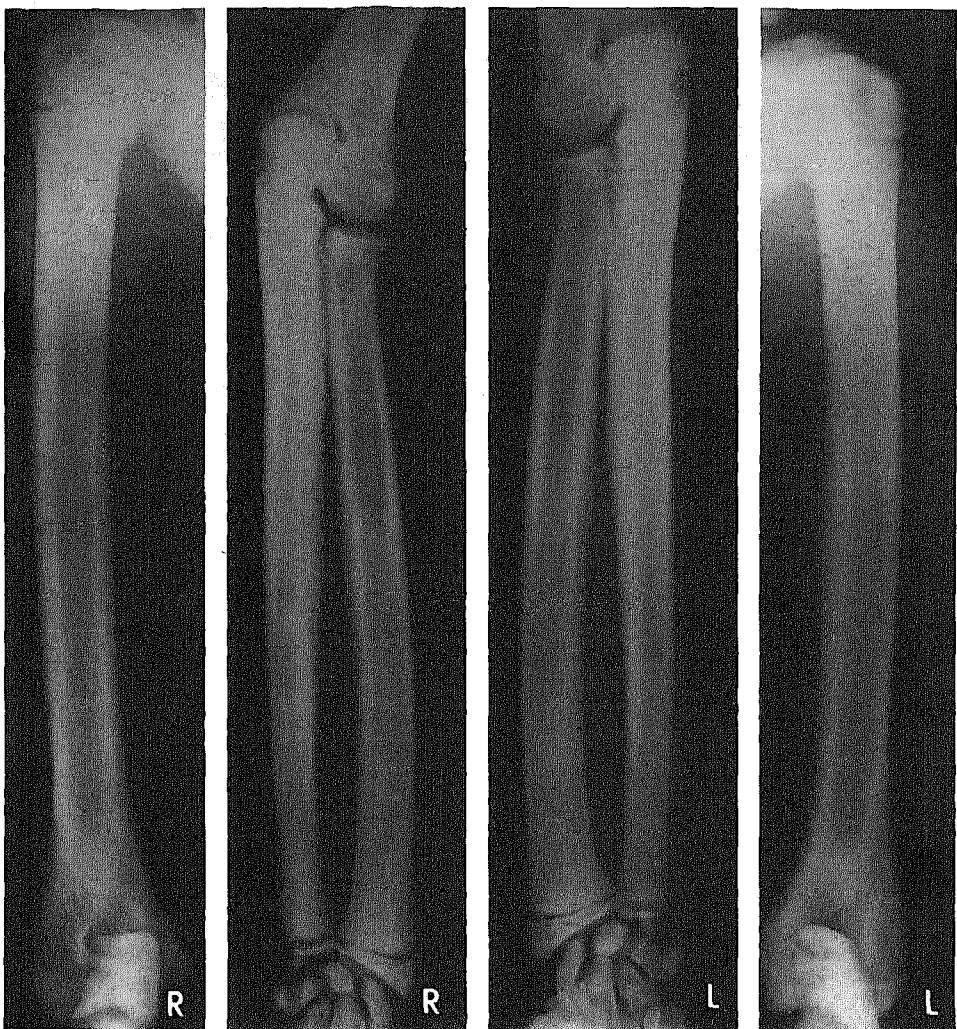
Arms and forearms, AP radiographs. The bones are sclerotic and relatively widened, particularly in the diaphyses, which accounts for the decreased modelling. While the cortices are thickened, the medullary cavities are in most areas only slightly expanded or of normal width. The epiphyseal ossification centers are much less affected than the rest of the bones and appear moderately flattened in the elbow and wrist.
